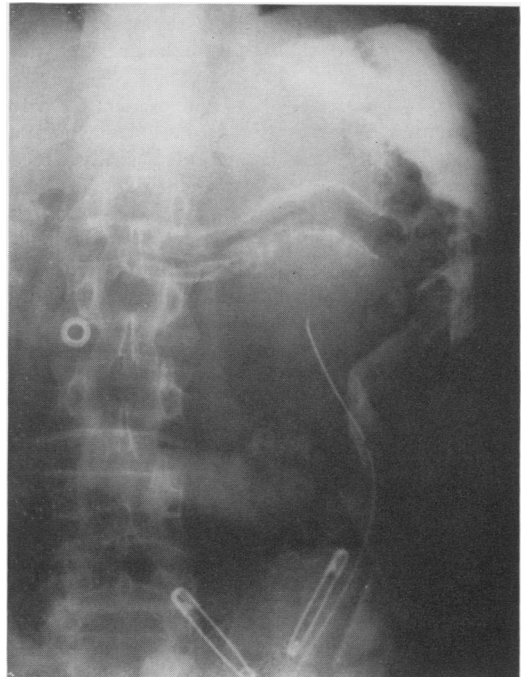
Case 2. X-ray of gastrograffin meal demonstrating extravasation of media from the stomach to the left subphrenic space.
